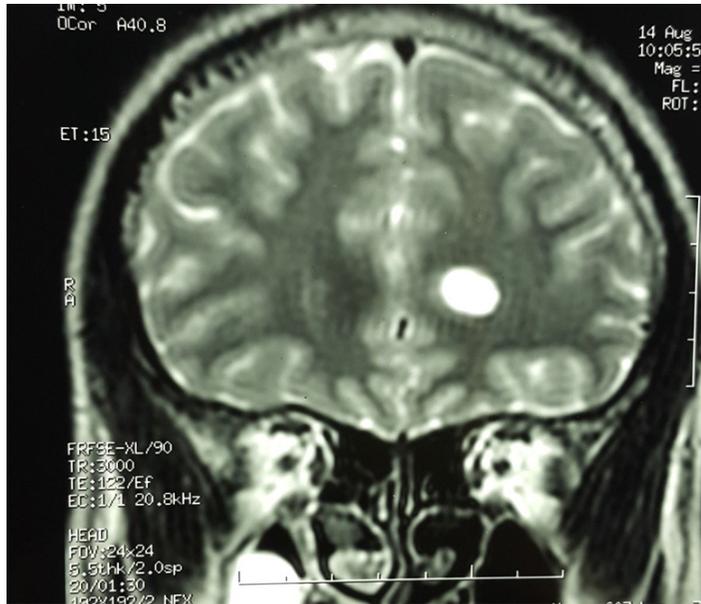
Brain MRI Demonstrating Intracranial Germinoma
